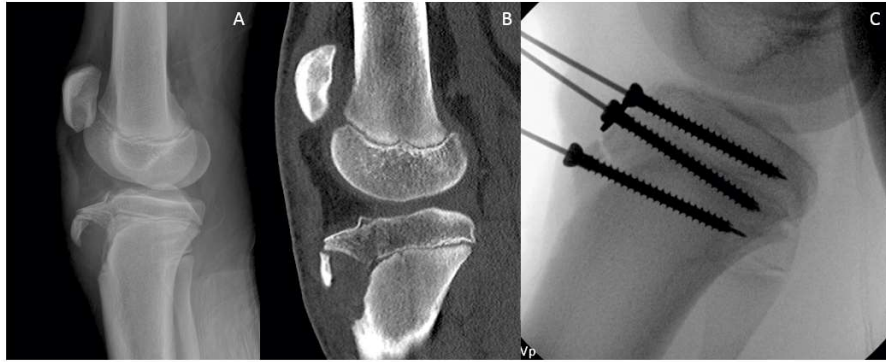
Lateral radiograph (A) and sagittal CT scan (B) demonstrating a displaced tibial tubercle fracture extending through the tubercle apophysis and into the anterior epiphysis, as well as an intraoperative lateral radiograph after reduction and screw fixation of the fracture (C).
